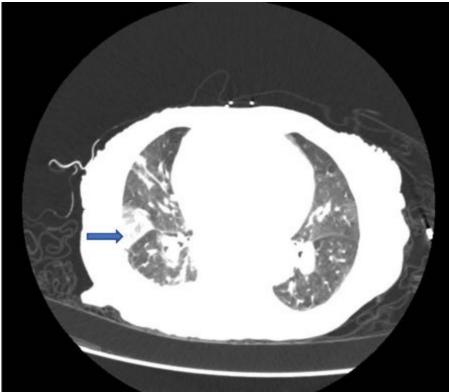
Computed tomography pulmonary angiogram showing wedge-shaped airspace opacity likely representing pulmonary infarction with possible overlying infection (arrow). Diffuse airspace opacities noted bilaterally, concerning for further infection.
